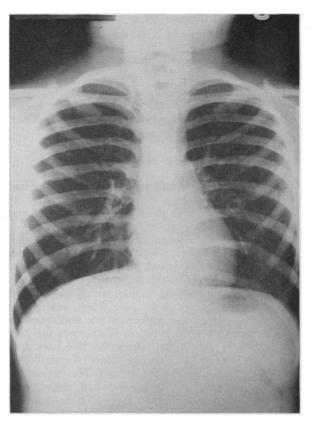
Roentgenogram of chest on January 24, 1958, showing complete expansion of lower left lobe and normal position of diaphragm and mediastinum.
